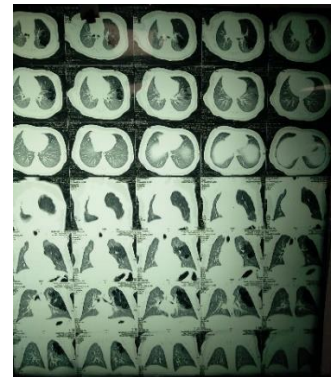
HRCT chest suggestive of left upper lobe and right middle lobe CCAM
